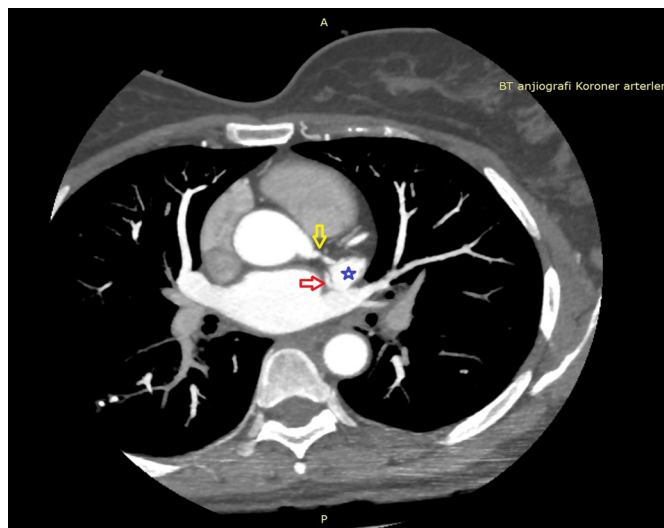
Case 2. Axial CT image. Blue star: LAA; red arrow: GCV; yellow arrow: left main coronary artery
